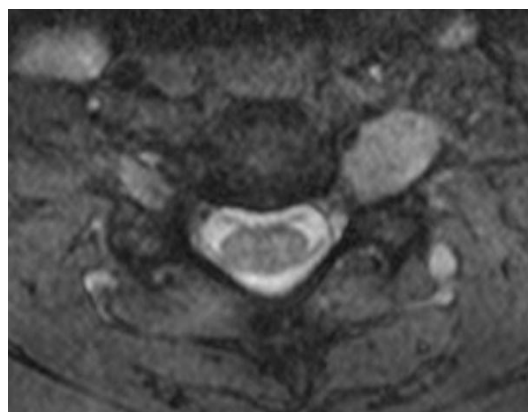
Axial T2W MRI sections showing an extradural tumour on left side of C5 body.
